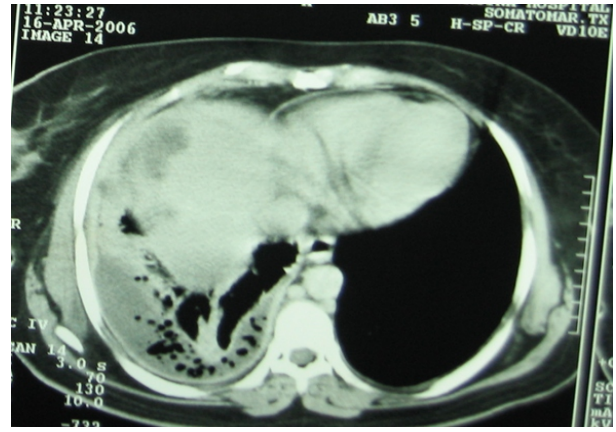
CT-scan, show pleural effusion caused by rupture of liver hydatid cyst in pleural space and daughter cysts
